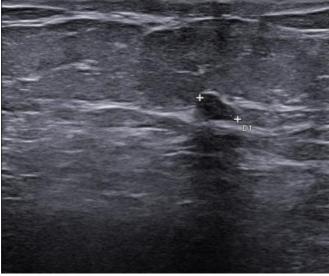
Last breast ultrasound performed, January 2025 (no significant detectable lesions).
